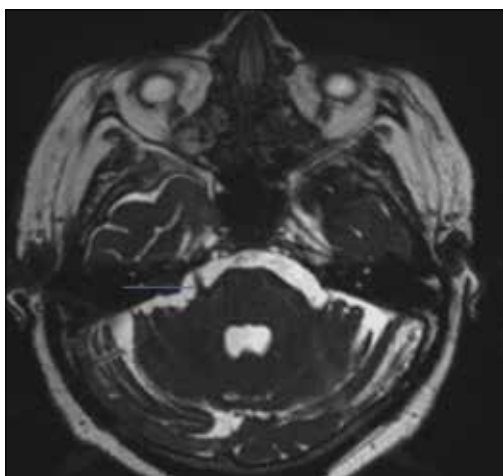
Magnetic resonance imaging brain three-dimensional FIESTA showing right trigeminal nerve (blue arrow)
